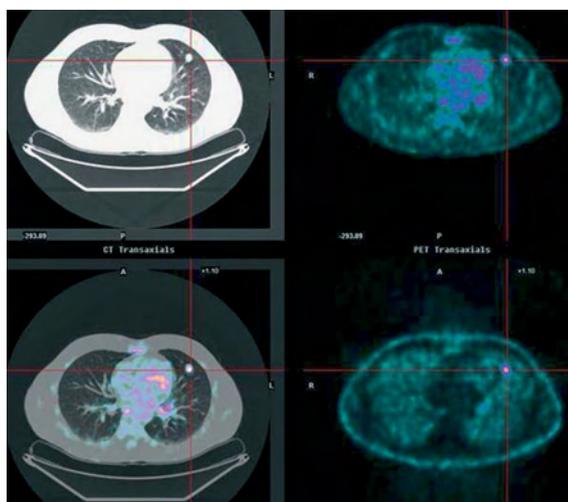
Solitary pulmonary nodule in the left lung with increased uptake of F-18-FDG (SUVmax 6.7)
